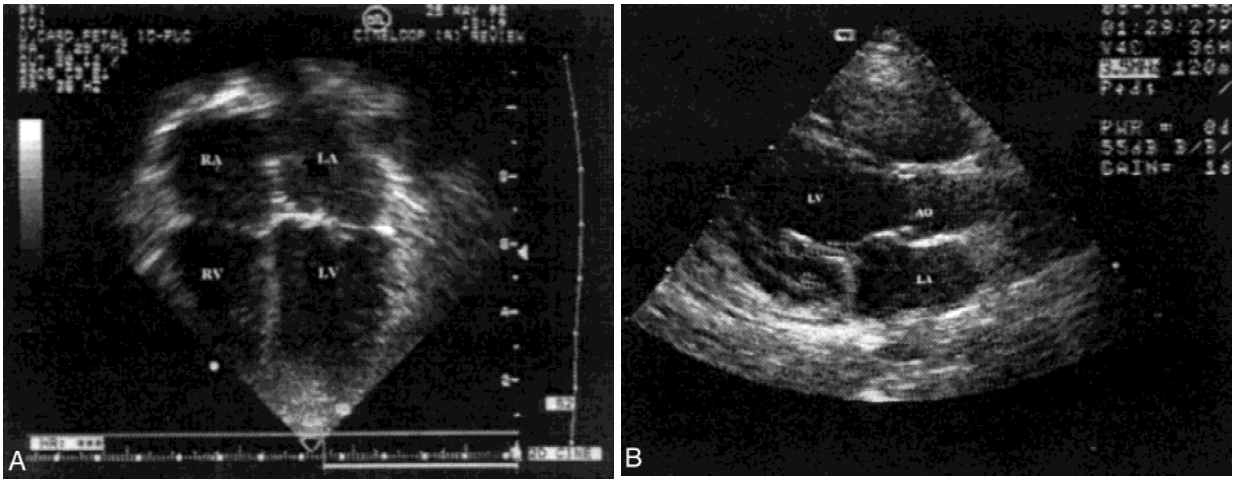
(A) Apical four-chamber view in patient No. 10 (see Table 1) showing the absence of regurgitation and adequate mitral valve function. (B) Parasternal long-axial view (systole) from patient No. 10 (see Table 1) showing nearly normal mitral apparatus. LA, left artery; LV, left ventricle; RA, right artery; RV, right ventricle.
